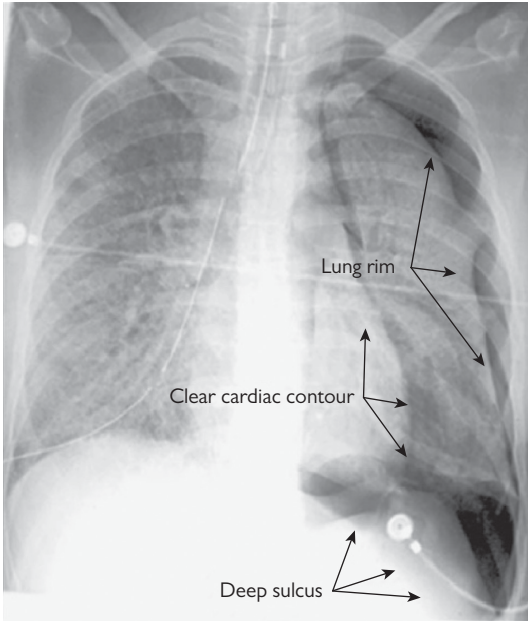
Chest X-ray appearance of pneumothorax.
